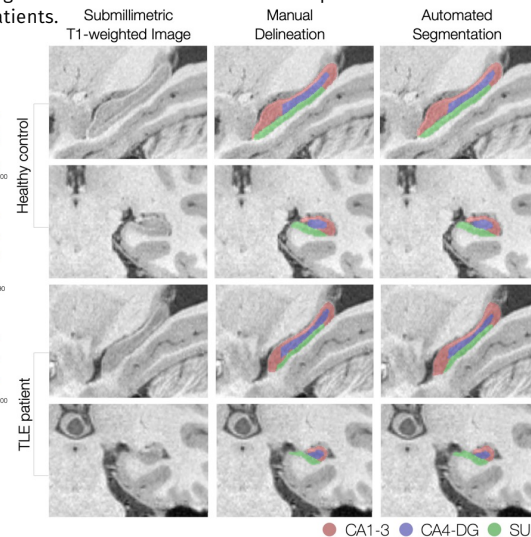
Manual delineation and DeepPatch automated segmentation relying on submillimetric T1-weighted MRI for a representative healthy control (CA1-3: 92.9%, CA4-DG: 89.7%, SUB: 91.2%) and a TLE patient (89.2%, 86.3%, 90.0%).
